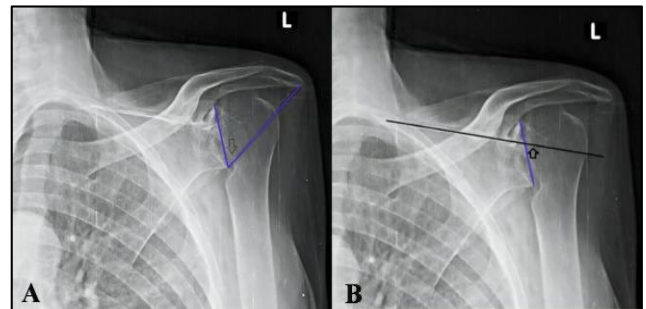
(A and B): Pre-operative radiographs of glenoid inclination measurement; CSA (black arrow) and beta angle (black arrow).
